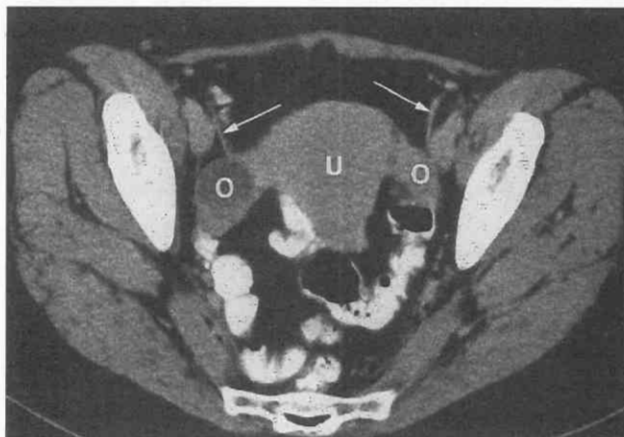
Normal anatomy. CT scan through the uterus (U) and ovaries (O) shows round ligaments (arrows) tapering anterolaterally over the external iliac vessels.
